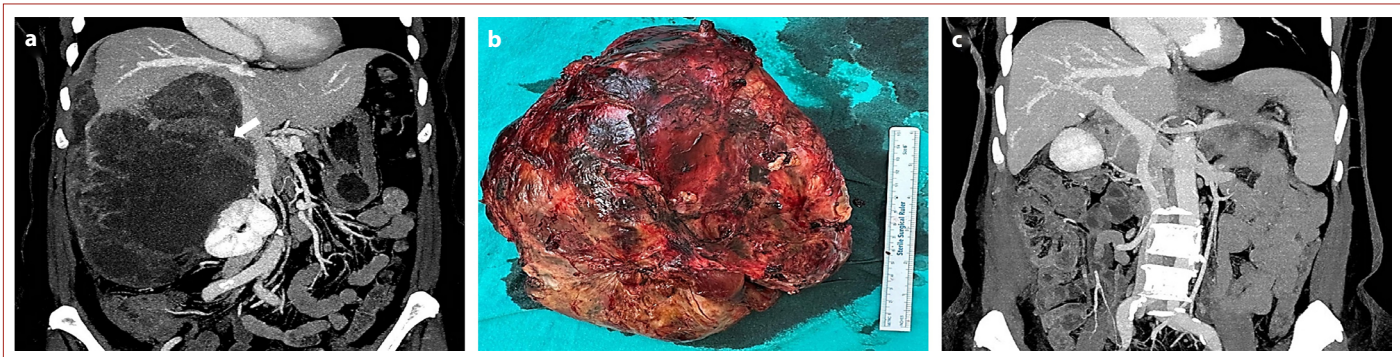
Summary of the large recurrent tumor. (a) The preoperative computerized tomography (CT) scan showing the large recurrent mass (arrow). (b) Shows the resection material intraoperatively. (c) Postoperative follow-up CT showing no recurrences.
